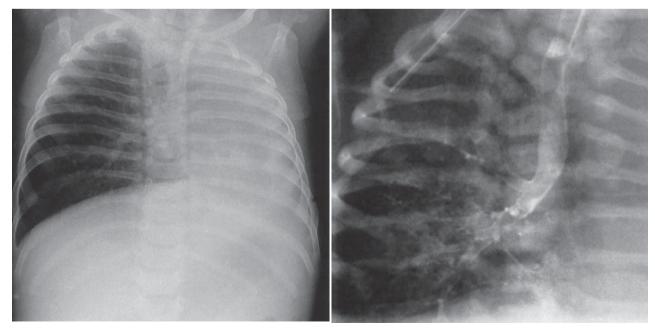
Left lung agenesis. Agenesis of the left lung with absence of the carina and left bronchial stump confirmed on tracheobronchogram. Note the associated vertebral anomaly, a common association with major airway abnormalities. Advanced imaging techniques such as CT scan have largely replaced bronchography.
